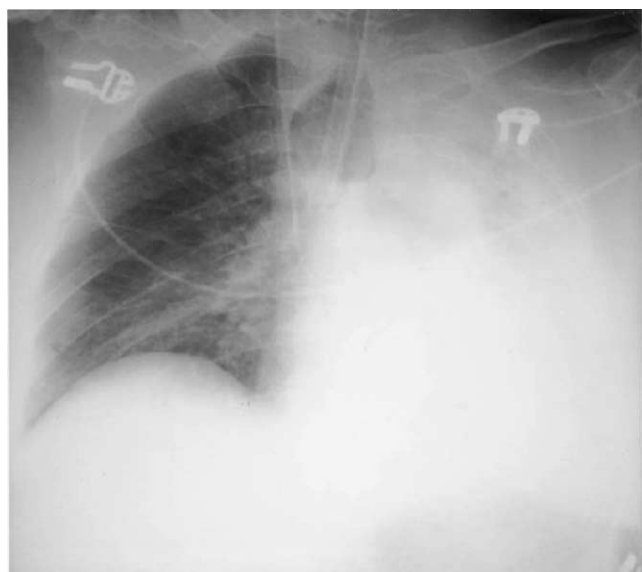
Typical X-rays after tracheal laceration: overinflated peer shaped cuff and atelectasis of the left side (type II).
